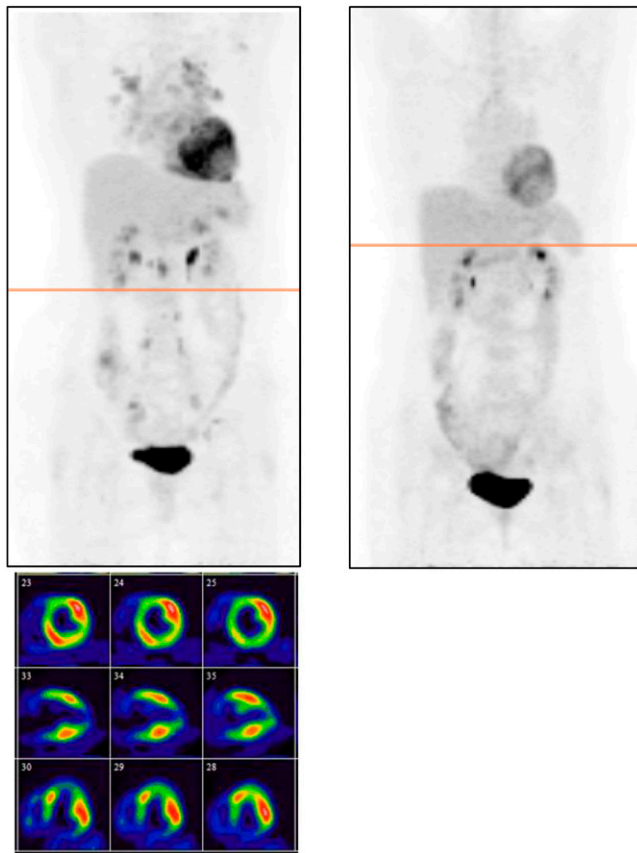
A 52-y-old woman who presented with atrial tachycardia and New York Heart Association class III congestive heart failure. High-resolution chest CT revealed pulmonary sarcoidosis. (Left) Extensive multifocal increased cardiac ^{18}F -FDG is seen on short-, horizontal-, and vertical-axis views (bottom) and on whole-body fasting ^{18}F -FDG PET (top), with increased pulmonary and hilar lymph nodes uptake. Findings were interpreted as positive for cardiac sarcoidosis. (Patient was considered positive according to MHLW guidelines.) (Right) Two months after treatment with prednisone (30 mg/d), marked improvement is seen in cardiac and pulmonary ^{18}F -FDG uptake.
